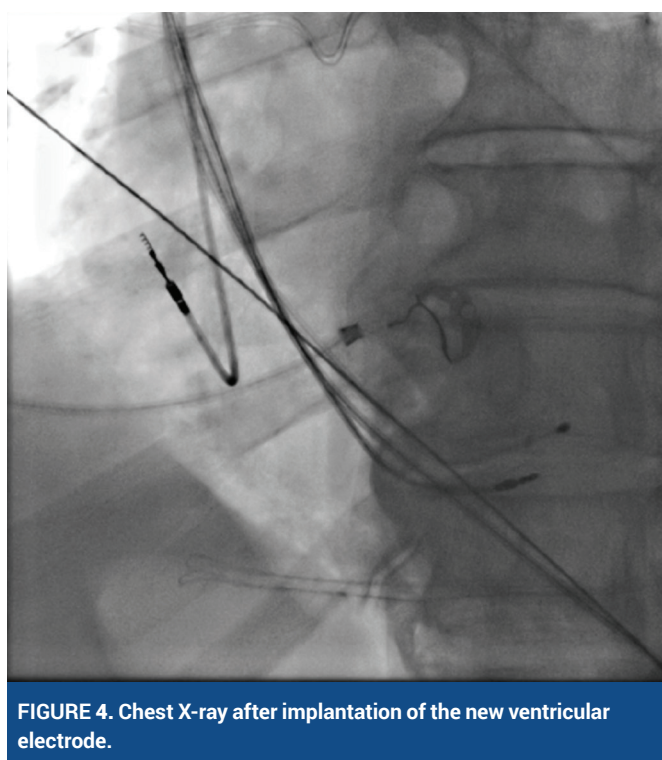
Chest X-ray after implantation of the new ventricular electrode.
